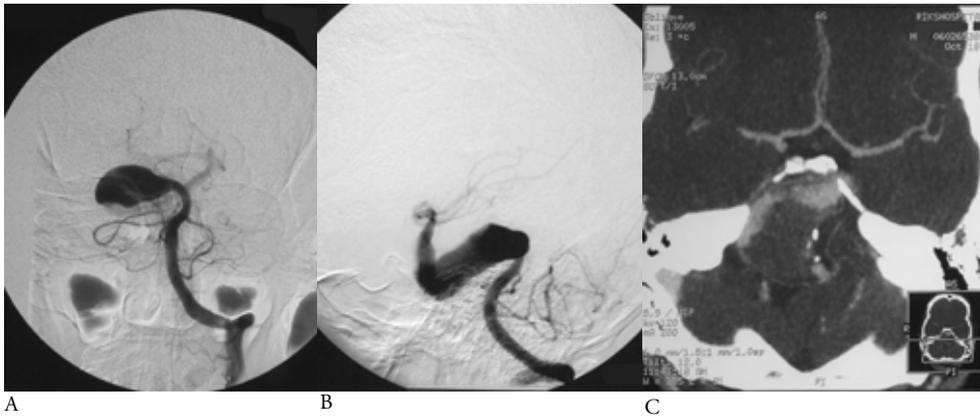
Pre-operative angiograms of the posterior circulation and a Computed Tomographic Angiogram of the circle of Willis. A) An early phase PA angiogram of the BA showing the aneurysm just distal of the AICA. B) A lateral angiogram in a slightly later phase shows the torticollous course of the aneurysm, with the origin of the SCA just distal of the aneurysm. C) The size of the aneurysm is much larger than suspected on angiography alone. Both thrombosed as well as non-thrombosed parts of the aneurysm are clearly visible.
